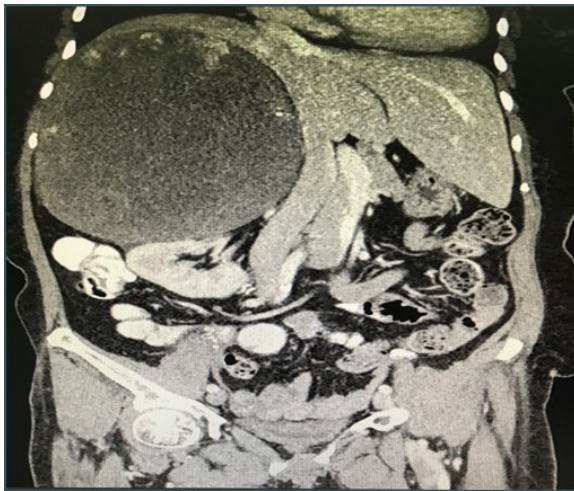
Coronal section CT scan showed huge hypodense mass located at right hypochondrium with increase vascularity at the periphery.
